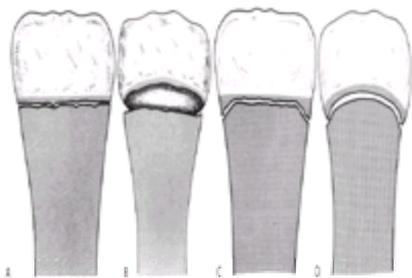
Metaphyseal lesions. A: A planar fracture through the primary spongiosa produces metaphyseal lucency. B: If the metaphysis is tipped, or simply projected at an obliquity to the x-ray beam, the margin of the resultant fragment is projected with a bucket-handle appearance. C: If the peripheral fragment is substantially thicker than the central fragment, and the plane of injury is viewed tangentially, a corner fracture appearance will result. D: If the metaphysis is displaced or projected at an obliquity, as in B, a thicker bucket handle will be apparent. (From ref. 16, with permission.)
